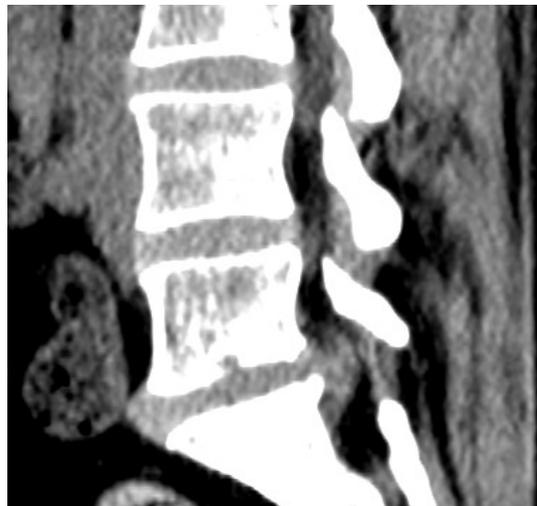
Sagittal Lumbar CT
